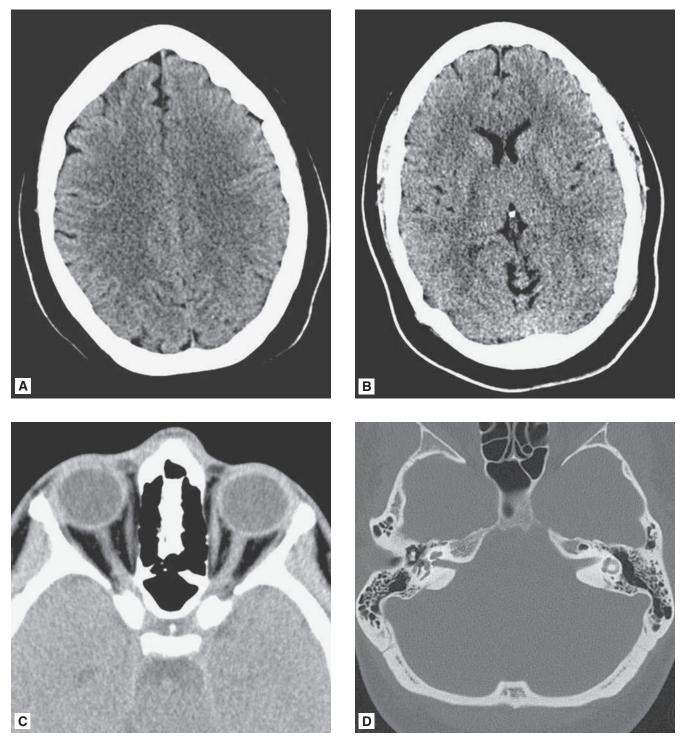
Normal CT in the axial plane of the brain, orbits, and skull base. *A*. Image through the cerebral hemispheres at the level of the corona radiata. The dense bone of the calvarium is white, and fat-containing subcutaneous tissue is dark. Gray matter appears denser than white matter due to its lower lipid content. *B*. Image at the level of the lenticular nuclei. The caudate and lenticular nuclei are denser than the adjacent internal capsule. CSF within the frontal horns of the lateral ventricles as well as surrounding the slightly calcified pineal body appears dark. *C*. Image through the mid-orbits. The sclera appears as a dense band surrounding the globe. The optic nerves are surrounded by dark orbital fat. The medial and lateral rectus muscles lie along the orbital walls and have a fusiform shape. Air within the nasopharynx and paranasal sinuses appears dark. *D*. Image at the base of the skull, digitally adjusted to visualize bone ("bone window"), showing the basal occipital and temporal bones, clivus, the bony structures of the posterior nasopharynx, aerated mastoid air cells, internal auditory canals and inner ear structures, as well as the sutures in the occipital bone.
